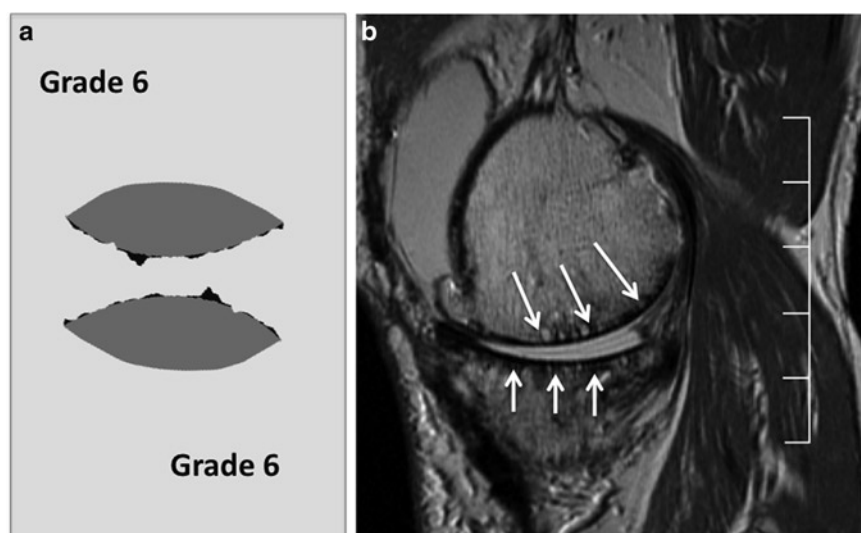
Whole-Organ-MRI-Score (WORMS) grade 6.* Graph of grade 6 knee cartilage lesions (a) and sagittal fat saturated intermediate weighted fast spin echo sequence of the knee (b) showing cartilage WORMS grade 6 lesions at the trochlea and patella (arrows). The full-thickness lesions affect more than 75% of the joint surfaces. The lesions would be classified as grade 3b lesions according to the modified Noyes and Stabler MRI score as they affect the entire cartilage layer and are associated with subchondral bone marrow edema pattern and cystic changes (trochlea). In addition, large osteophytes are demonstrated
